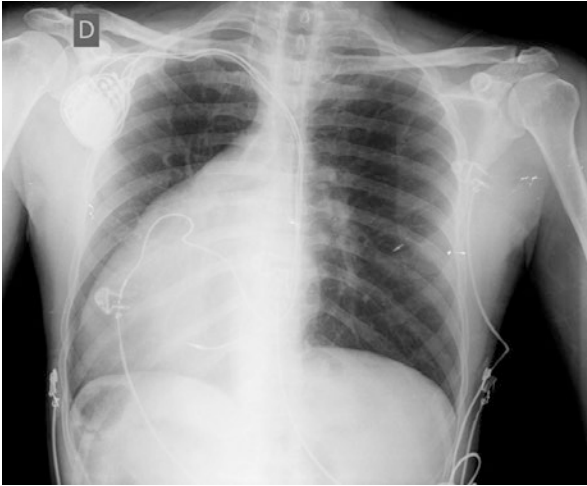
Initial chest radiography showing an enlarged cardiac silhouette, with the base-apex axis pointing to the right (dextrocardia). The aortic arch and the gastric bubble are seen on the right as well
